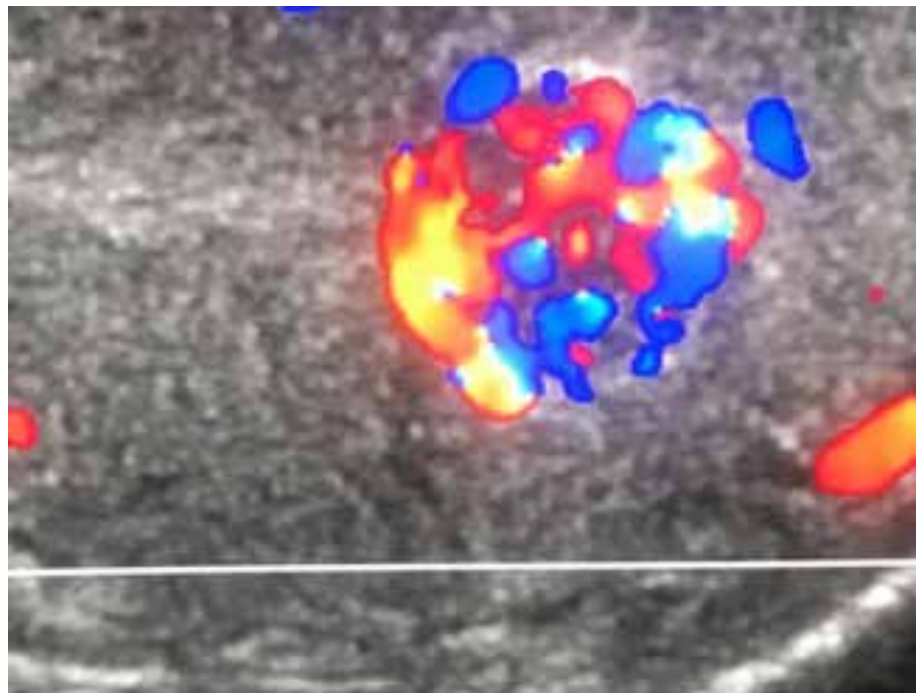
Black arrow demonstrates tumour hypervascularisation on colour Doppler flow imaging.
